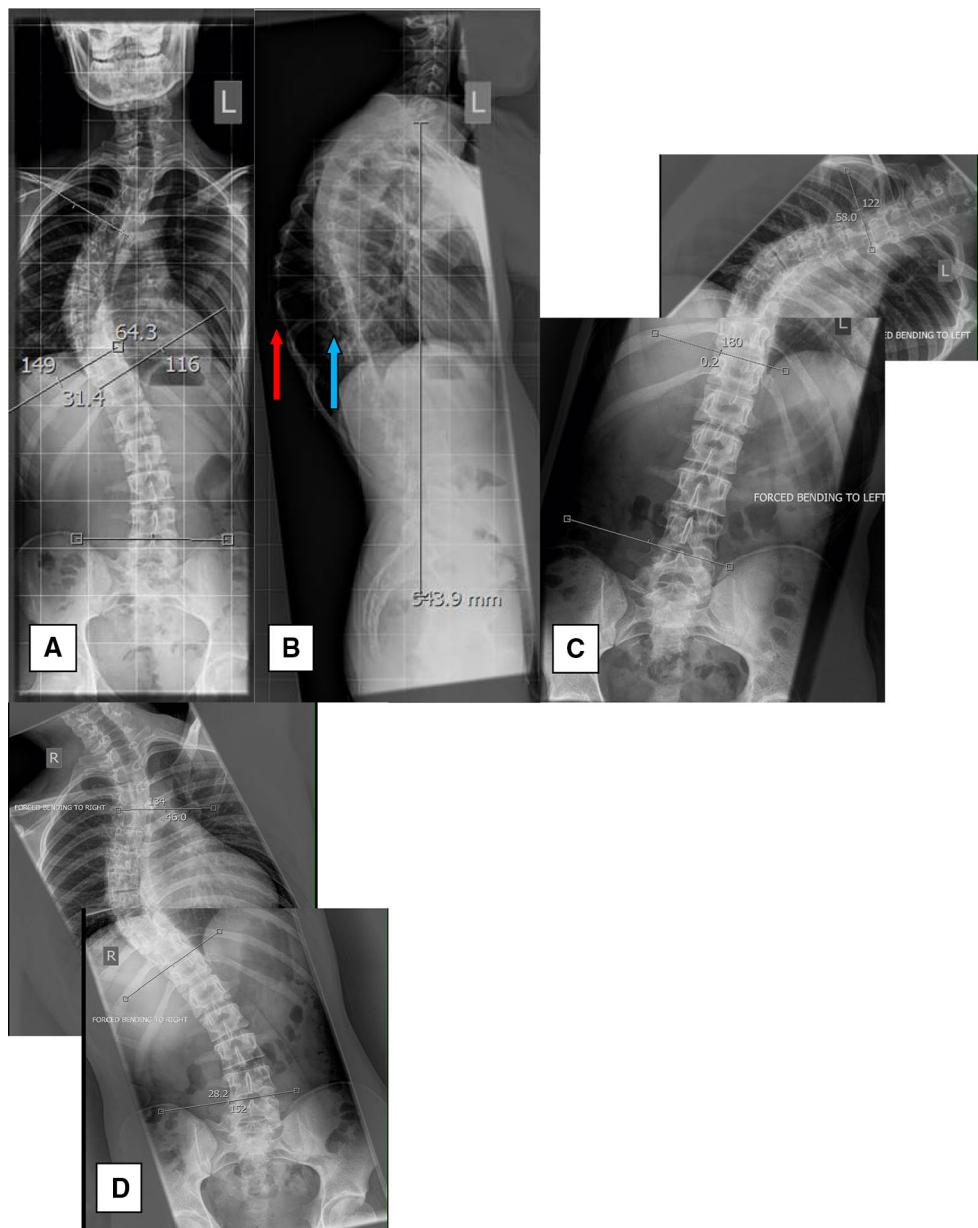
Pre-operative X-rays. a Anterior posterior image, 64° right thoracic curve, b lateral image, neutral sagittal balance, large rib cage asymmetry—red arrow convex side ribs, blue arrow concave side
